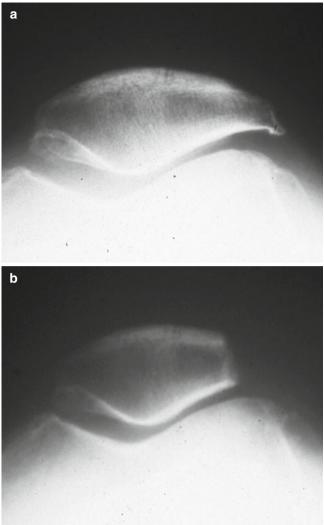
Preoperative (a) and postoperative (b) x-rays (skyline views)
